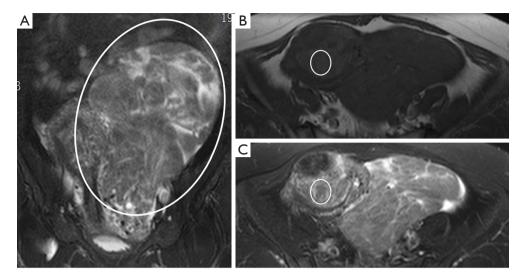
Magnetic resonance imaging. (A) The circle refers to an irregular mixed signal masse in the pelvic cavity on coronal T2FS. (B) The circle refers to adipose tissue in the mass with high signal intensity on T1W images. (C) The circle refers to adipose tissue in the mass with suppressed and hypointense on T1FS. T2FS, T2-weighted image with fat-suppression; T1W, T1-weighted; T1FS, T1-weighted image with fat-suppression.
